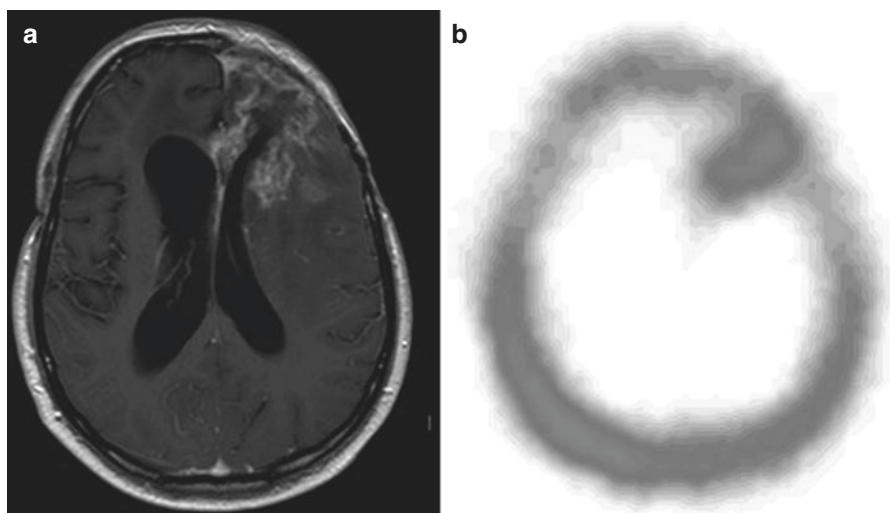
(a) Gadolinium-enhanced T1-weighted MRI revealing recurrence of an anaplastic oligoastrocytoma. (b) ^{99m}Tc -tetrofosmin brain SPECT revealing increased tracer uptake in the corresponding area
